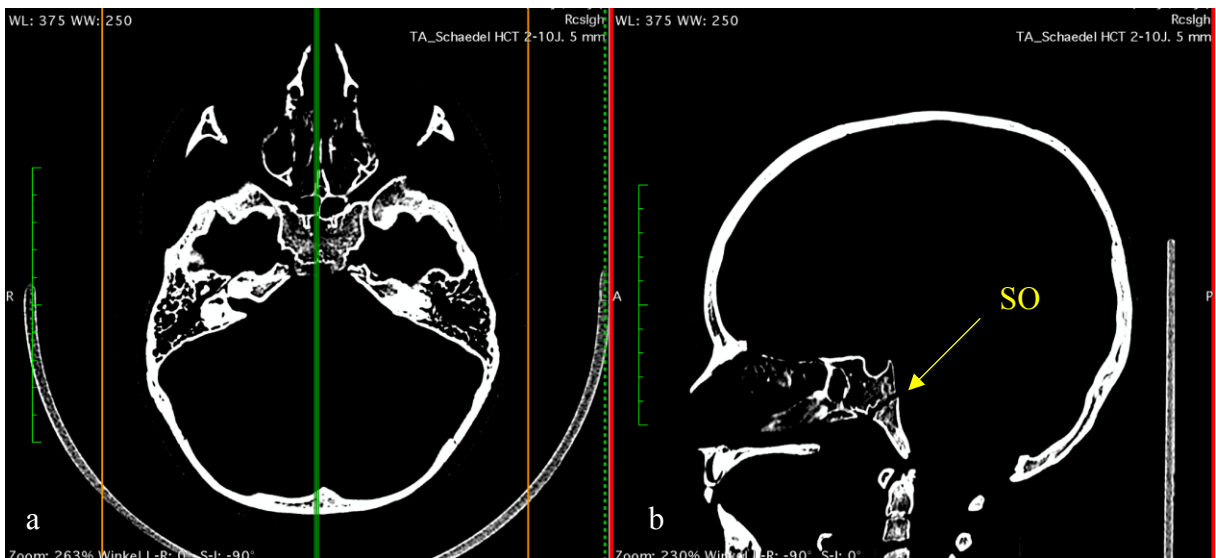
CT image of a pediatric skull of a 4 years old male in manual WW/WL setting in a axial view and b sagittal reformat (yellow arrow: sphenooipital suture).
